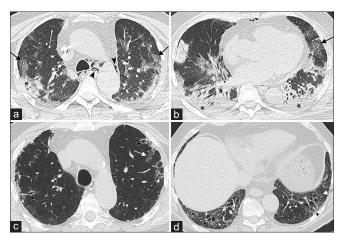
A 63-year-old male with COVID-19 pneumonia. (a and b) Axial contrast-enhanced chest CT images demonstrate bilateral upper lobe-predominant ground-glass opacities (black arrows) and lower lobe-predominant consolidation (*), consistent with COVID-19 and acute lung injury. Pneumomediastinum is also visible (black arrowheads). (c) Axial noncontrast chest CT image through the upper lobes, performed 7 months after initial CT, demonstrates peripheral predominant ground-glass opacities (white arrows) and reticulation (white arrowheads), associated with architectural distortion and traction bronchiectasis/ bronchiolectasis (black arrowheads), consistent with pulmonary fibrosis. (d) Axial noncontrast chest CT image through the lower lobes, performed 7 months after initial CT, shows more pronounced fibrosis, characterized by GGO (white arrow) and reticulation (white arrowheads) with architectural distortion and traction bronchisetasis/bronchiolectasis (black arrowheads). GGO: ground-glass opacity, CT: Computed tomography
